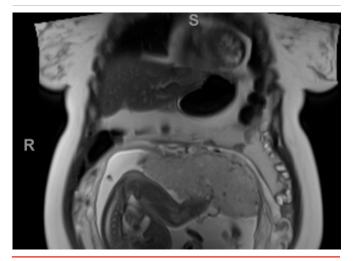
Sagittal View of T2-Weighted MRI (arrow indicating pheochromocytoma). Published with Permission
